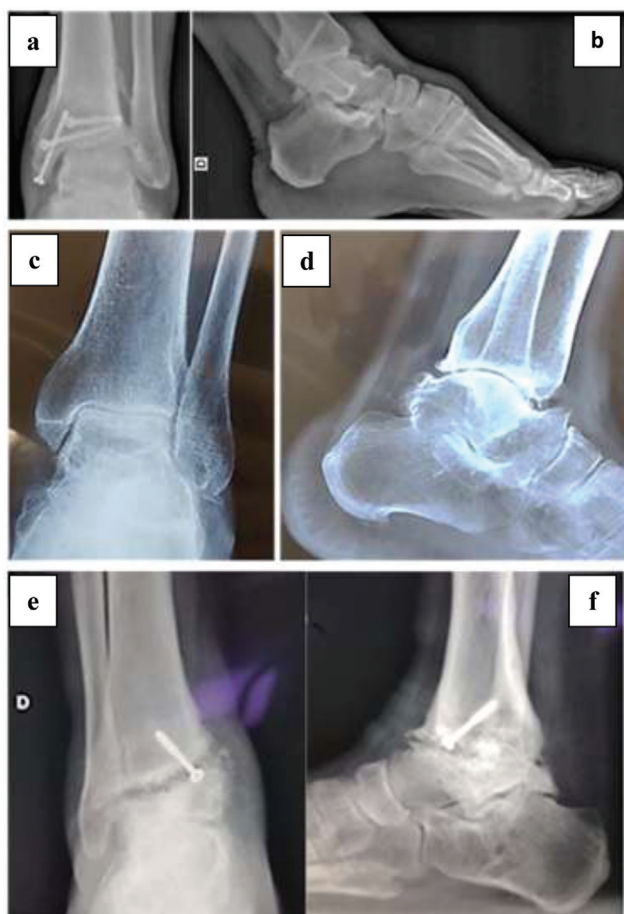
Preoperative radiographic aspect: case 1 – sequela of tibial pylon fracture (a, b); case 2 – chronic ankle instability (c, d); and case 3 – failure in tibiotalar arthrodesis (e, f).
